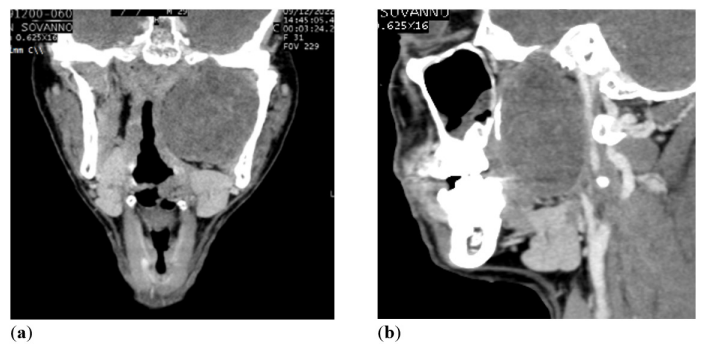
Preoperative CT scan demonstrating well-defined heterogeneous hypodense mass located in the left parapharyngeal space, measuring approximately 73 × 60 × 46 mm: (a) coronal view; (b) sagittal view.
